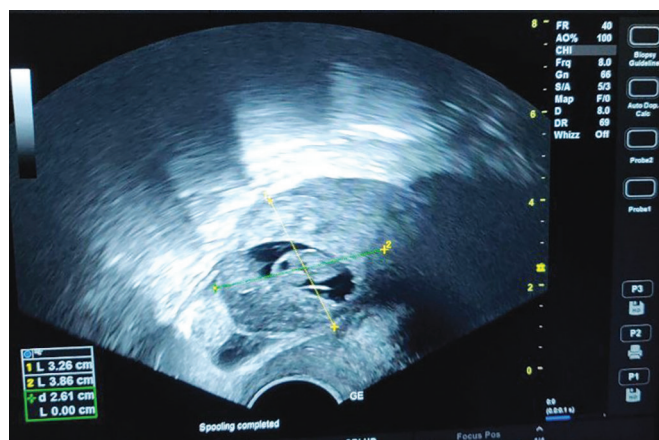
Pelvic ultrasound findings. Abdominal ectopic pregnancy adherent to the posterior wall of the uterus measuring 3.26 cm × 3.86 cm
